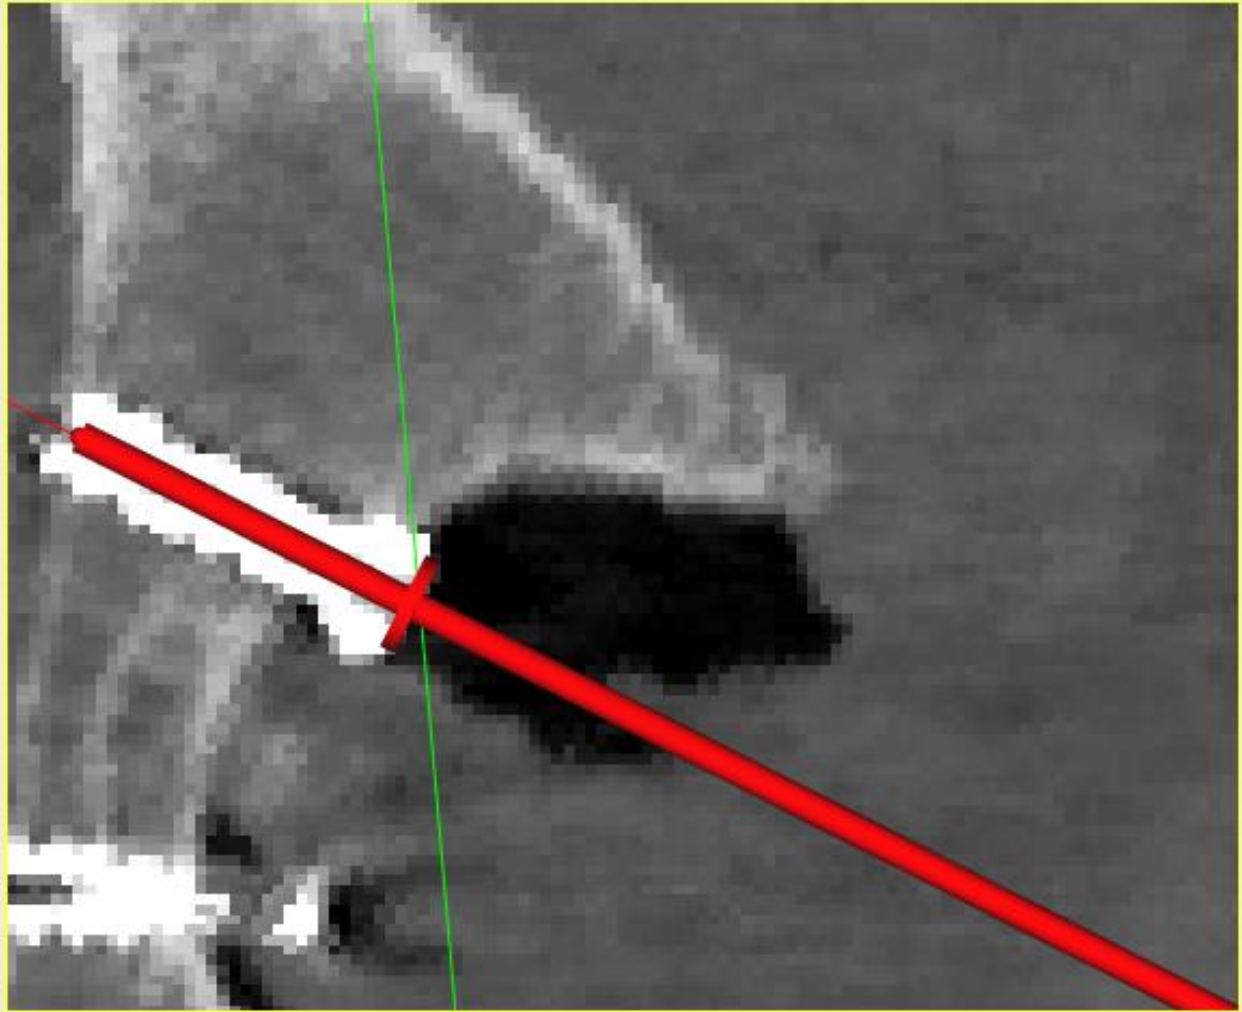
2D cross-sectional view of CT study showing calculation of the post-operative screw placement.
